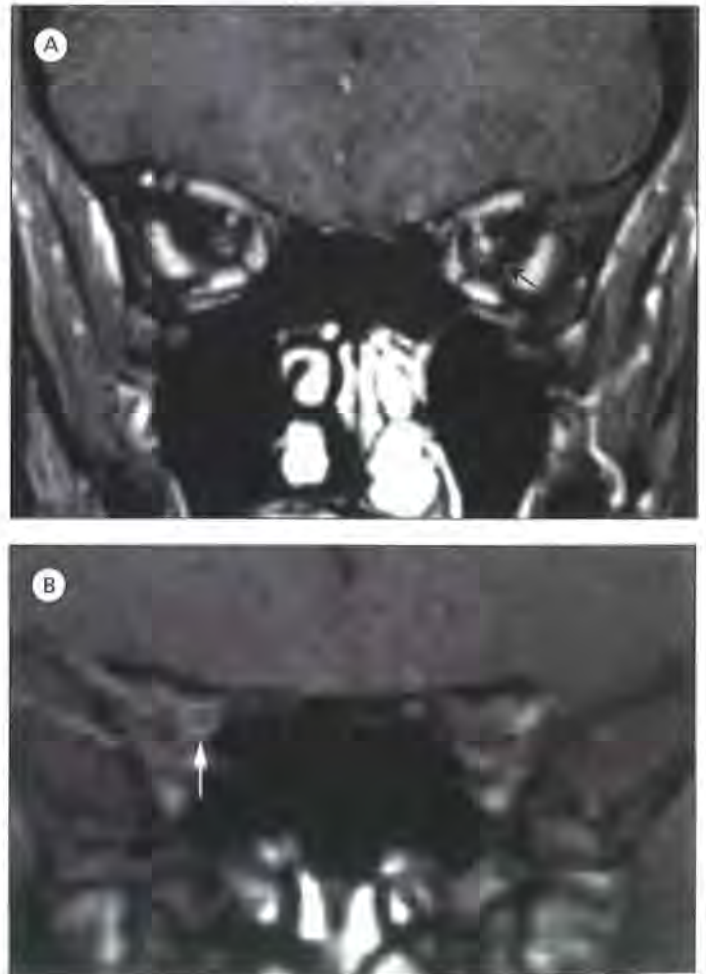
Triple-dose gadolinium enhanced coronal T₁-weighted MRI in two cases of acute optic neuritis. (A) Homogeneous enhancement of the left optic nerve. (B) Enhancement of the right optic nerve sheath (arrowed).
